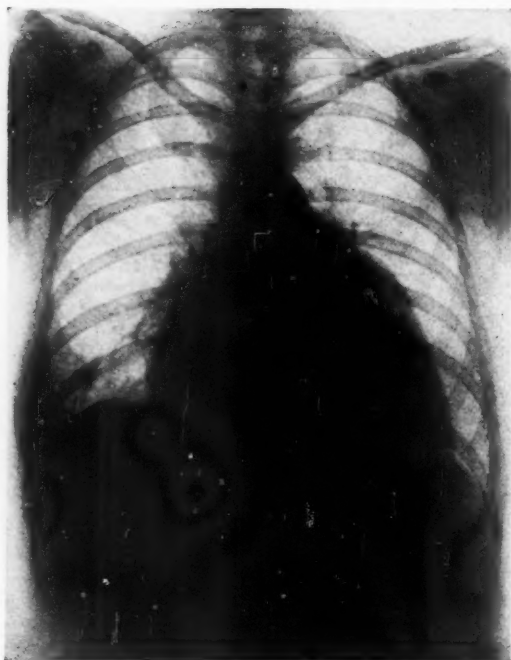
Roentgenogram made on admission, showing typical mitral configuration of cardiac silhouette.
